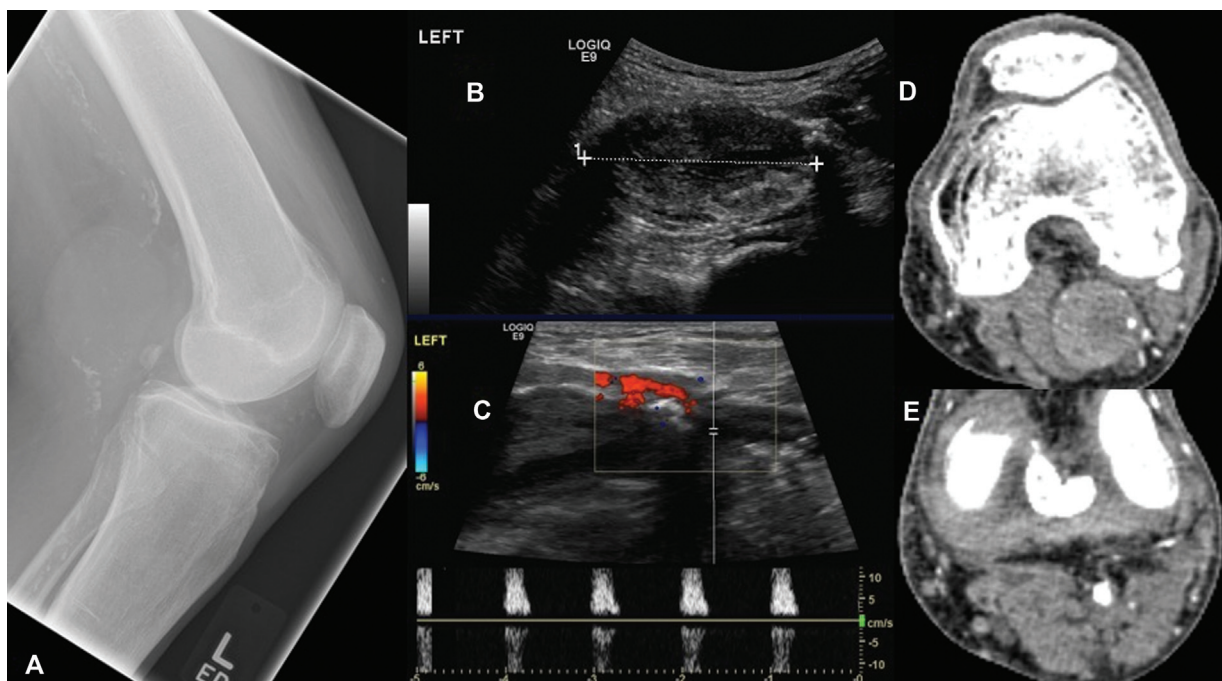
Popliteal artery aneurysm: The lateral knee radiograph (A) showing vascular calcification and globular aneurysmal shadow inseparable from the popliteal artery shadow. Grayscale (B) and color Doppler (C) ultrasound image showing a heterogenous popliteal artery aneurysm with partial thrombosis, confirmed on axial computed tomography angiogram images (D, E) showing near-completely occluded popliteal artery aneurysm.
